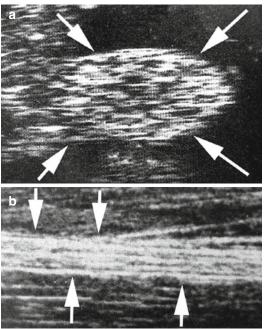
(a) High-resolution ultrasound image of sciatic nerve in cross section. Note ability to visualize fascicular pattern (*arrows*). (b) High-resolution ultrasound image of sciatic nerve in longitudinal section (*arrows*) (Adapted from Graif et al. [10])
